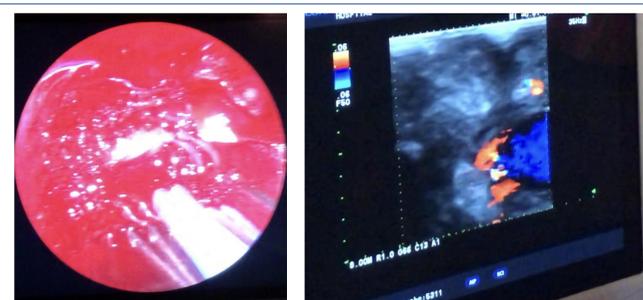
Use of intraoperative ultrasound during endoscopic skull base surgery.
